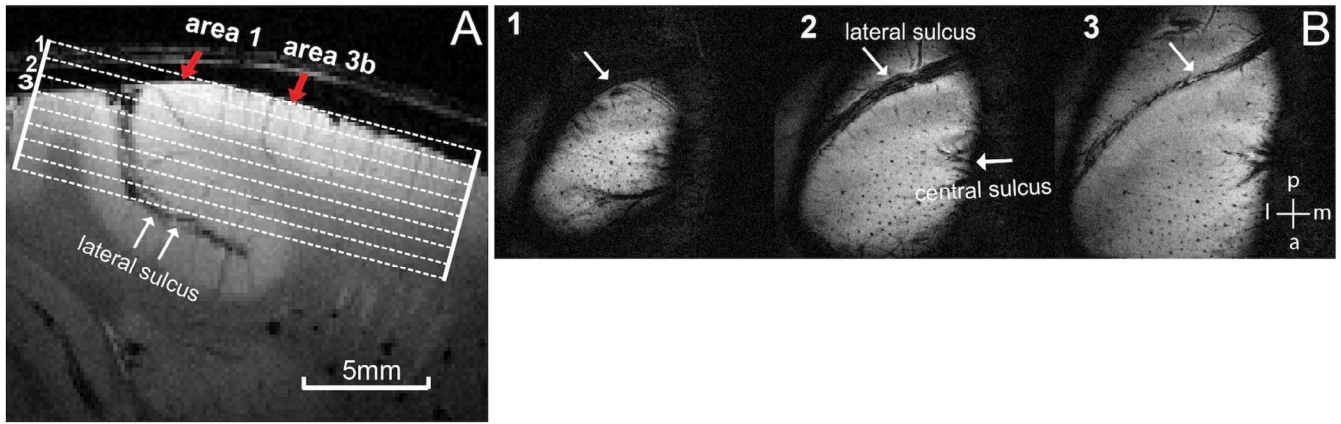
MRI acquisition field of view (FOV) for laminar data. (A) Coronal view of the imaging plane showing a slice thickness of 0.667 mm with an in-plane resolution of $0.547 \times 0.547 \text{ mm}^2$ for oblique images covering area 3b and area 1. (B) Axial view of the top three slices of the T_2 weighted anatomic image showing the S1 cortex (area 3b & 1).
